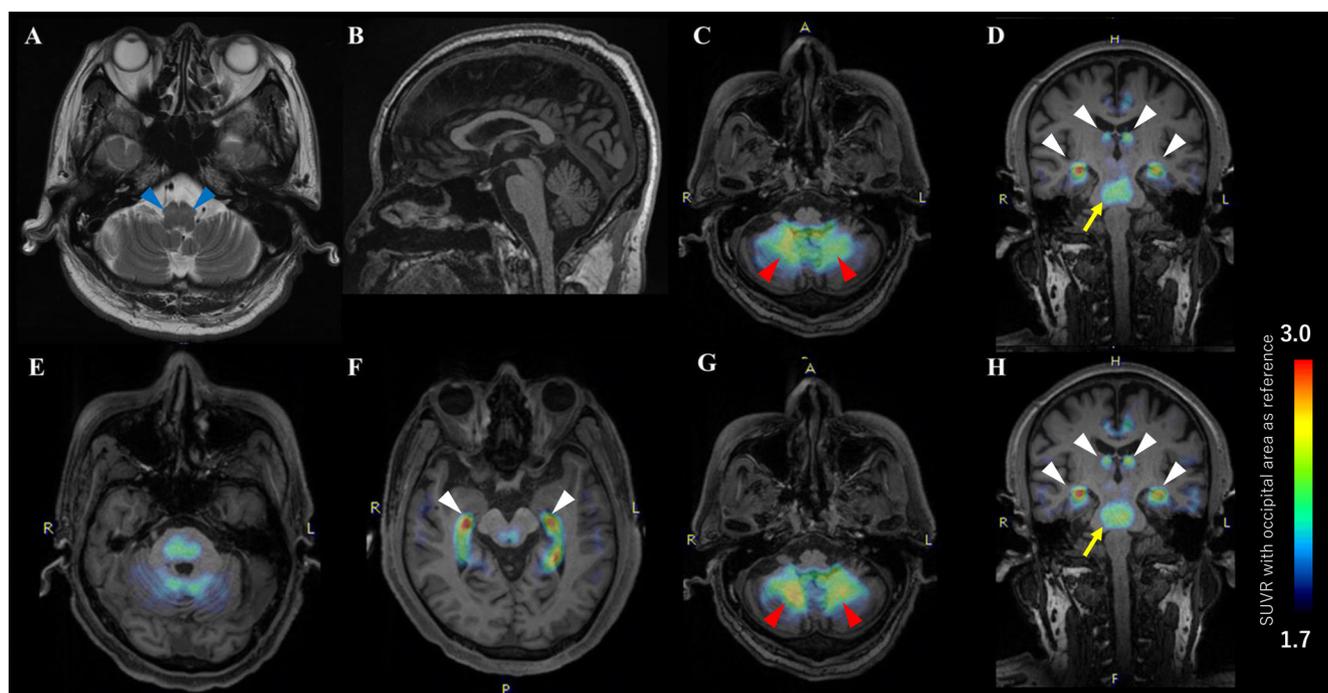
The patient's brain MRI findings and [¹⁸F]PM-PBB3 tau PET scan. Brain MRI showed increased signal intensity on T2-weighted sequences, hypertrophy of the bilateral IONs (blue arrowheads) (A), and mild cerebellar atrophy (B). Accumulation of [¹⁸F]PM-PBB3 was detected in the dentate nucleus (C, red arrowheads), pontine central tegmentum tract (D,E, yellow arrow), red nucleus (F), and cerebellar cortex (C,E). A very low accumulation of [¹⁸F]PM-PBB3 was detected in the thalamus, subthalamic nucleus, globus pallidus (D), and substantia nigra (F). Two years after the first [¹⁸F]PM-PBB3 PET examination, the patient's follow-up tau PET showed slightly increased accumulation in the dentate nucleus (G, red arrow heads) and pontine central tegmentum tract (H, yellow arrow). White arrowheads point to the choroid plexus (non-specific binding) (D,F,H).
